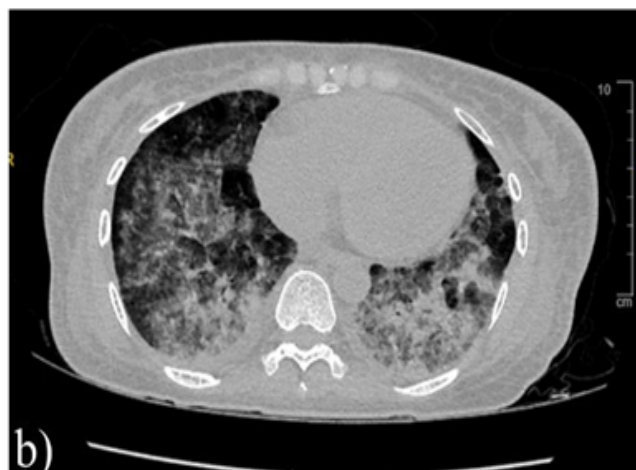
Axial computed tomography of the chest showing “crazy paving” of bilateral lower zones, in line with pulmonary haemorrhage
